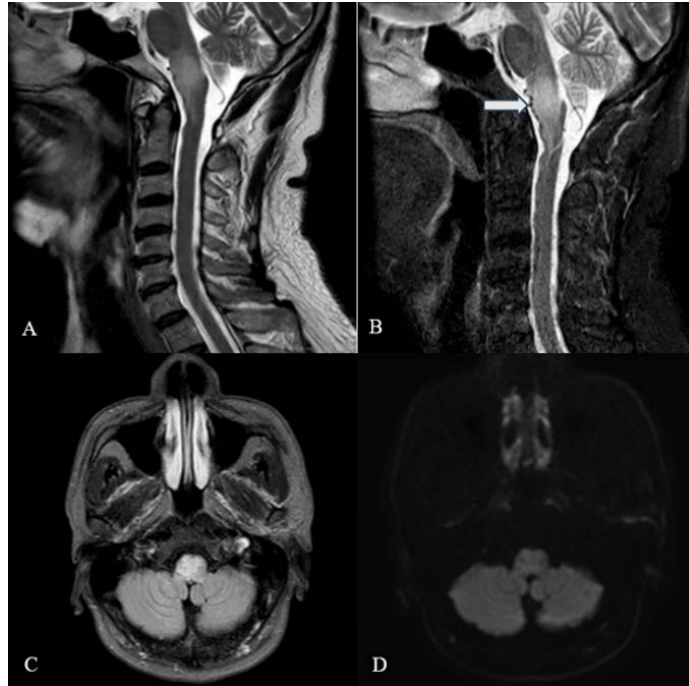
A 62-year-old male patient with Cognard type V dAVF: MRI findings at admission. (A), (B): Sagittal T2-Weighted (A) and STIR (B) images show a hyperintense lesion in the medulla oblongata and upper cervical spinal cord at C1-C2, with several small flow voids representing dilated vessels along the anterior surface of the medulla (large white arrows), which were initially overlooked. (C), (D): Axial FLAIR images show hyperintensity without diffusion restriction on DWI.
